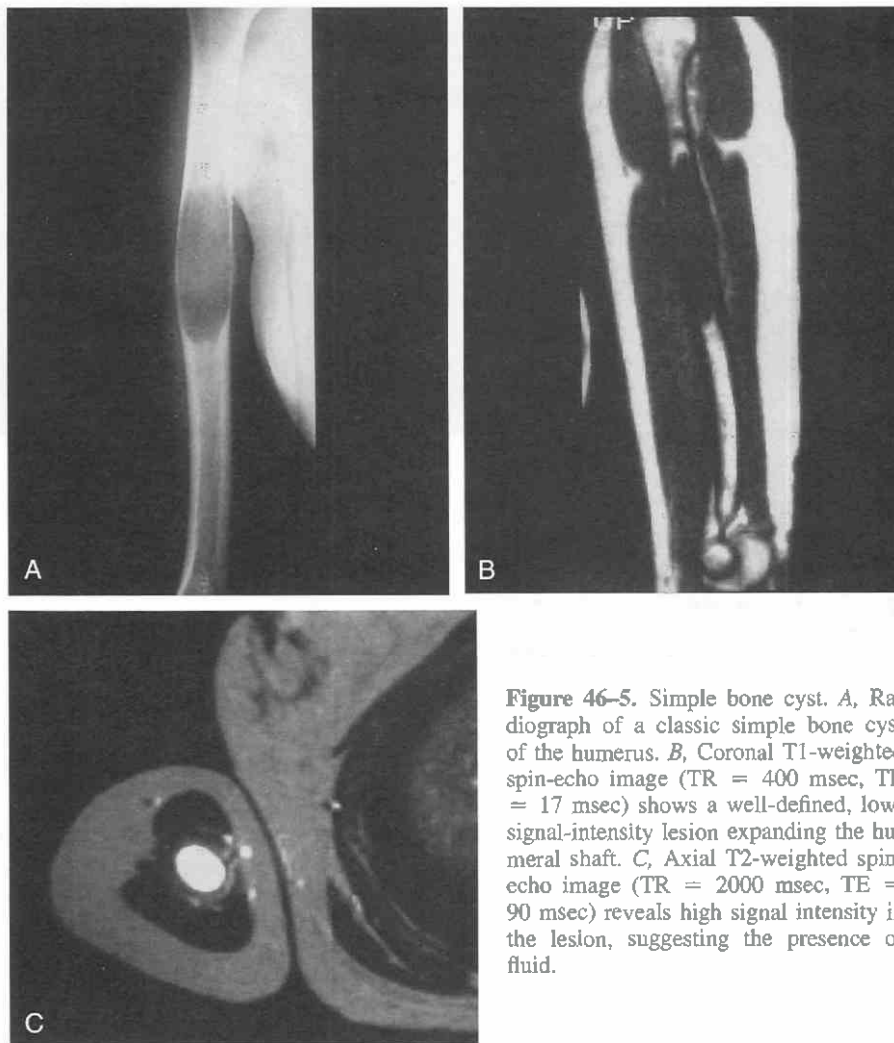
Simple bone cyst. *A*, Radiograph of a classic simple bone cyst of the humerus. *B*, Coronal T1-weighted spin-echo image (TR = 400 msec, TE = 17 msec) shows a well-defined, low-signal-intensity lesion expanding the humeral shaft. *C*, Axial T2-weighted spin-echo image (TR = 2000 msec, TE = 90 msec) reveals high signal intensity in the lesion, suggesting the presence of fluid.
